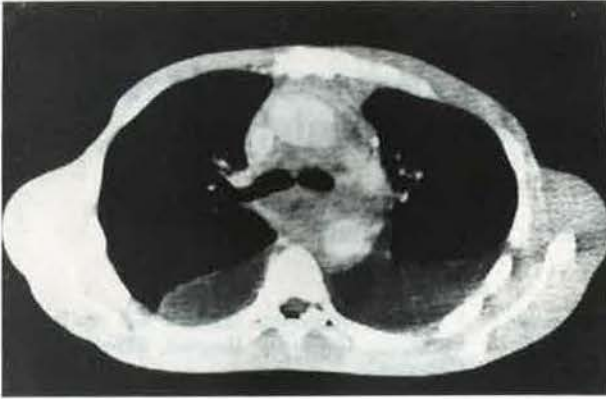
Computed tomographic scan of the thorax: bilateral pleural effusion and a broadened mediastinum.
